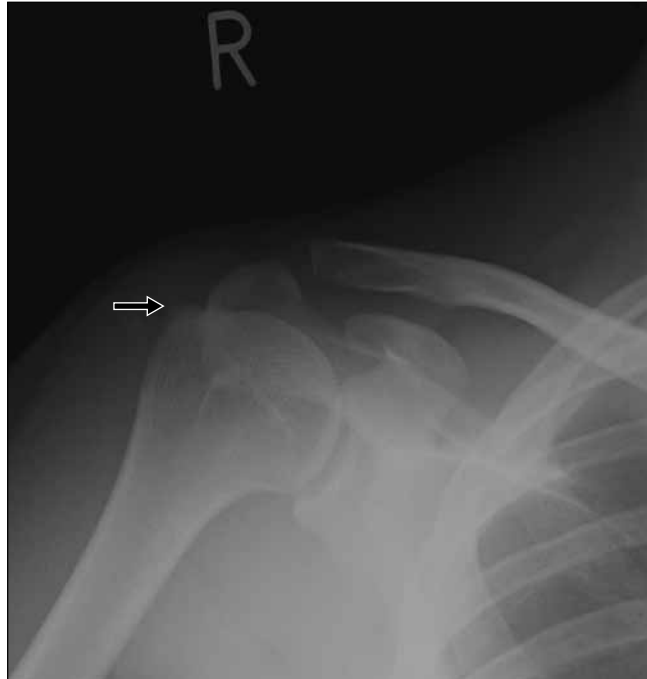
Frontal radiograph of the right shoulder obtained immediately after the road traffic accident, three months after the initial presentation of shoulder pain.
